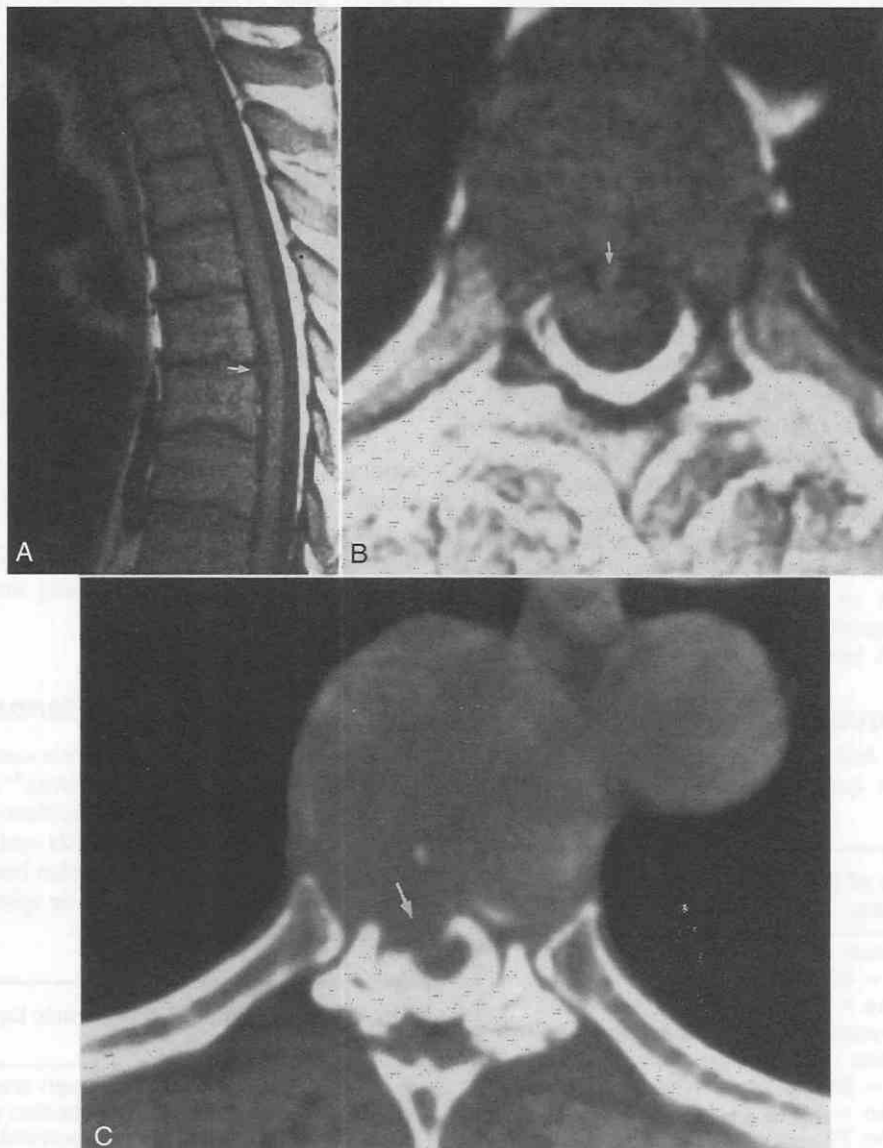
Sagittal (A) and axial (B) T1-weighted MR images of central disk herniation (*arrows*). C, Postmyelogram CT scan of slightly lateral disk herniation (*arrow*).
